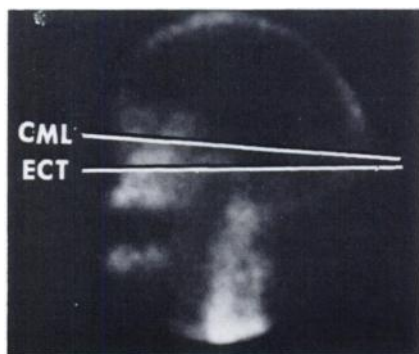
Relationship of canthomeatal line to plane of reconstructions presented in this paper. (CML) canthomeatal line; (ECT) plane in emission computed tomography.
